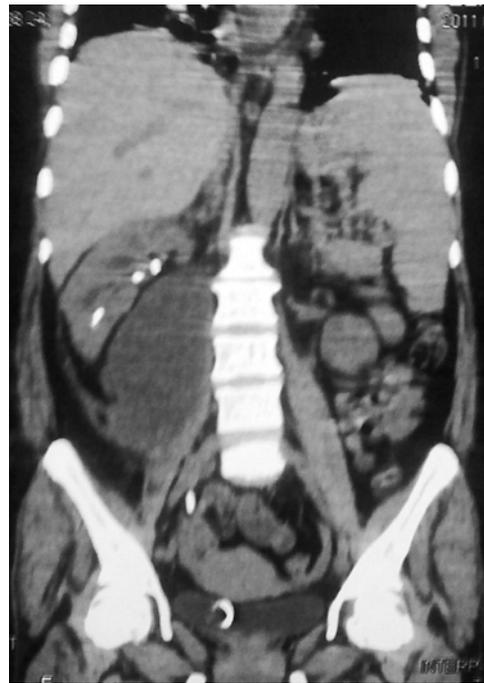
Unenhanced CT with coronal reconstruction showing stone in pelvic course of left ureter.
